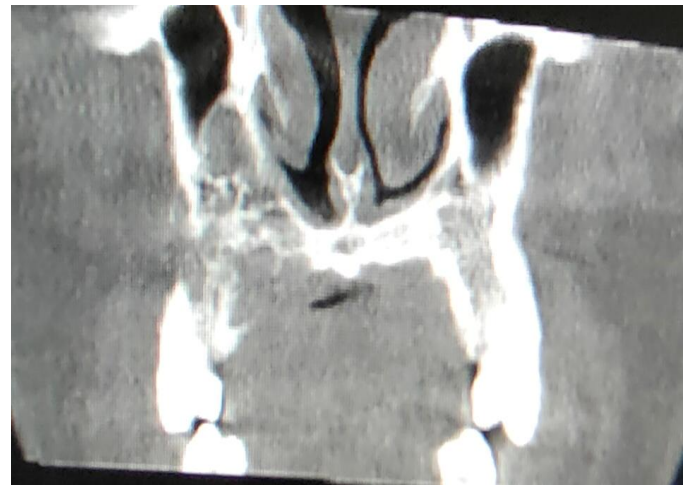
CBCT coronal view
